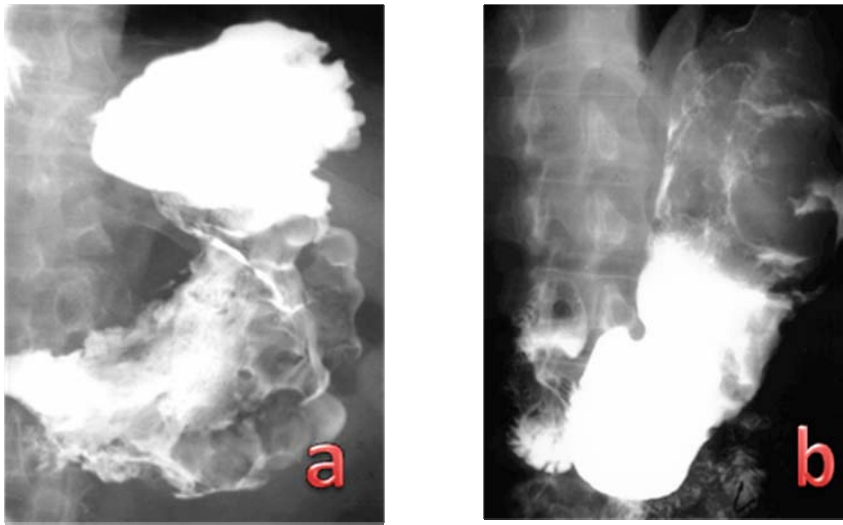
High-grade gastric MALT lymphoma: a) Radiography shows diffuse, homogeneous thickened folds with a mass and lobulated inner surface of a gastric wall in the corpus and antrum of the stomach, b) Radiography shows a mass with nodular margins in the fornix and corpus of the stomach
